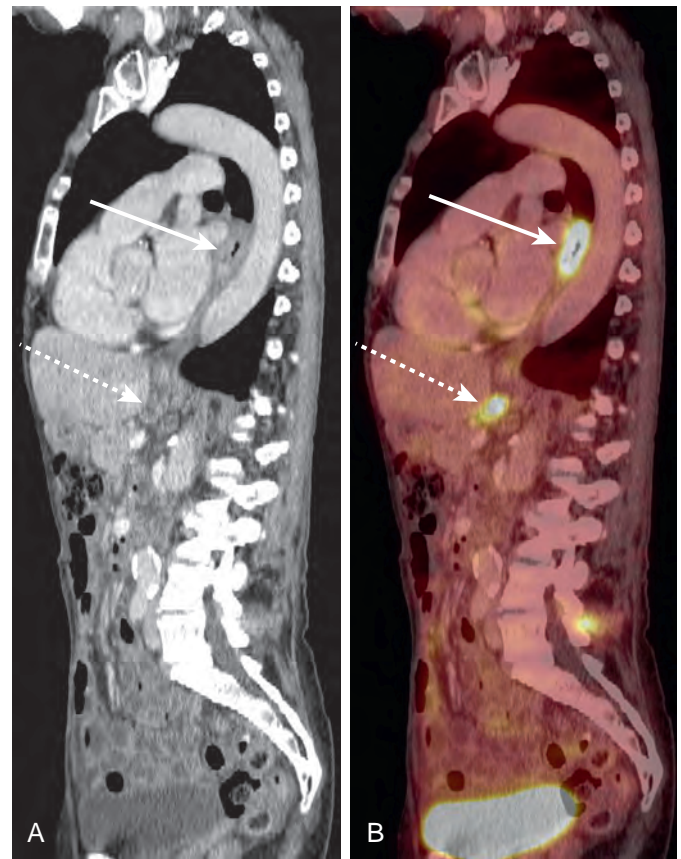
Midesophageal cancer. A. Sagittal contrast-enhanced CT scan demonstrates focal circumferential thickening of the midesophagus (solid arrow) suspicious for malignancy. A large, suspicious, low-density gastrohepatic lymph node (dashed arrow) is also seen. B. Corresponding sagittal fused PET/CT image shows intense FDG uptake in the midesophagus (solid arrow) and in a gastrohepatic lymph node (dashed arrow).
